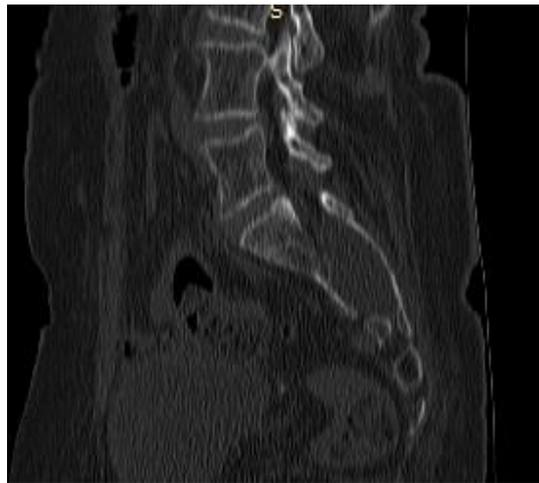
CT preoperatoria sagital cut.
